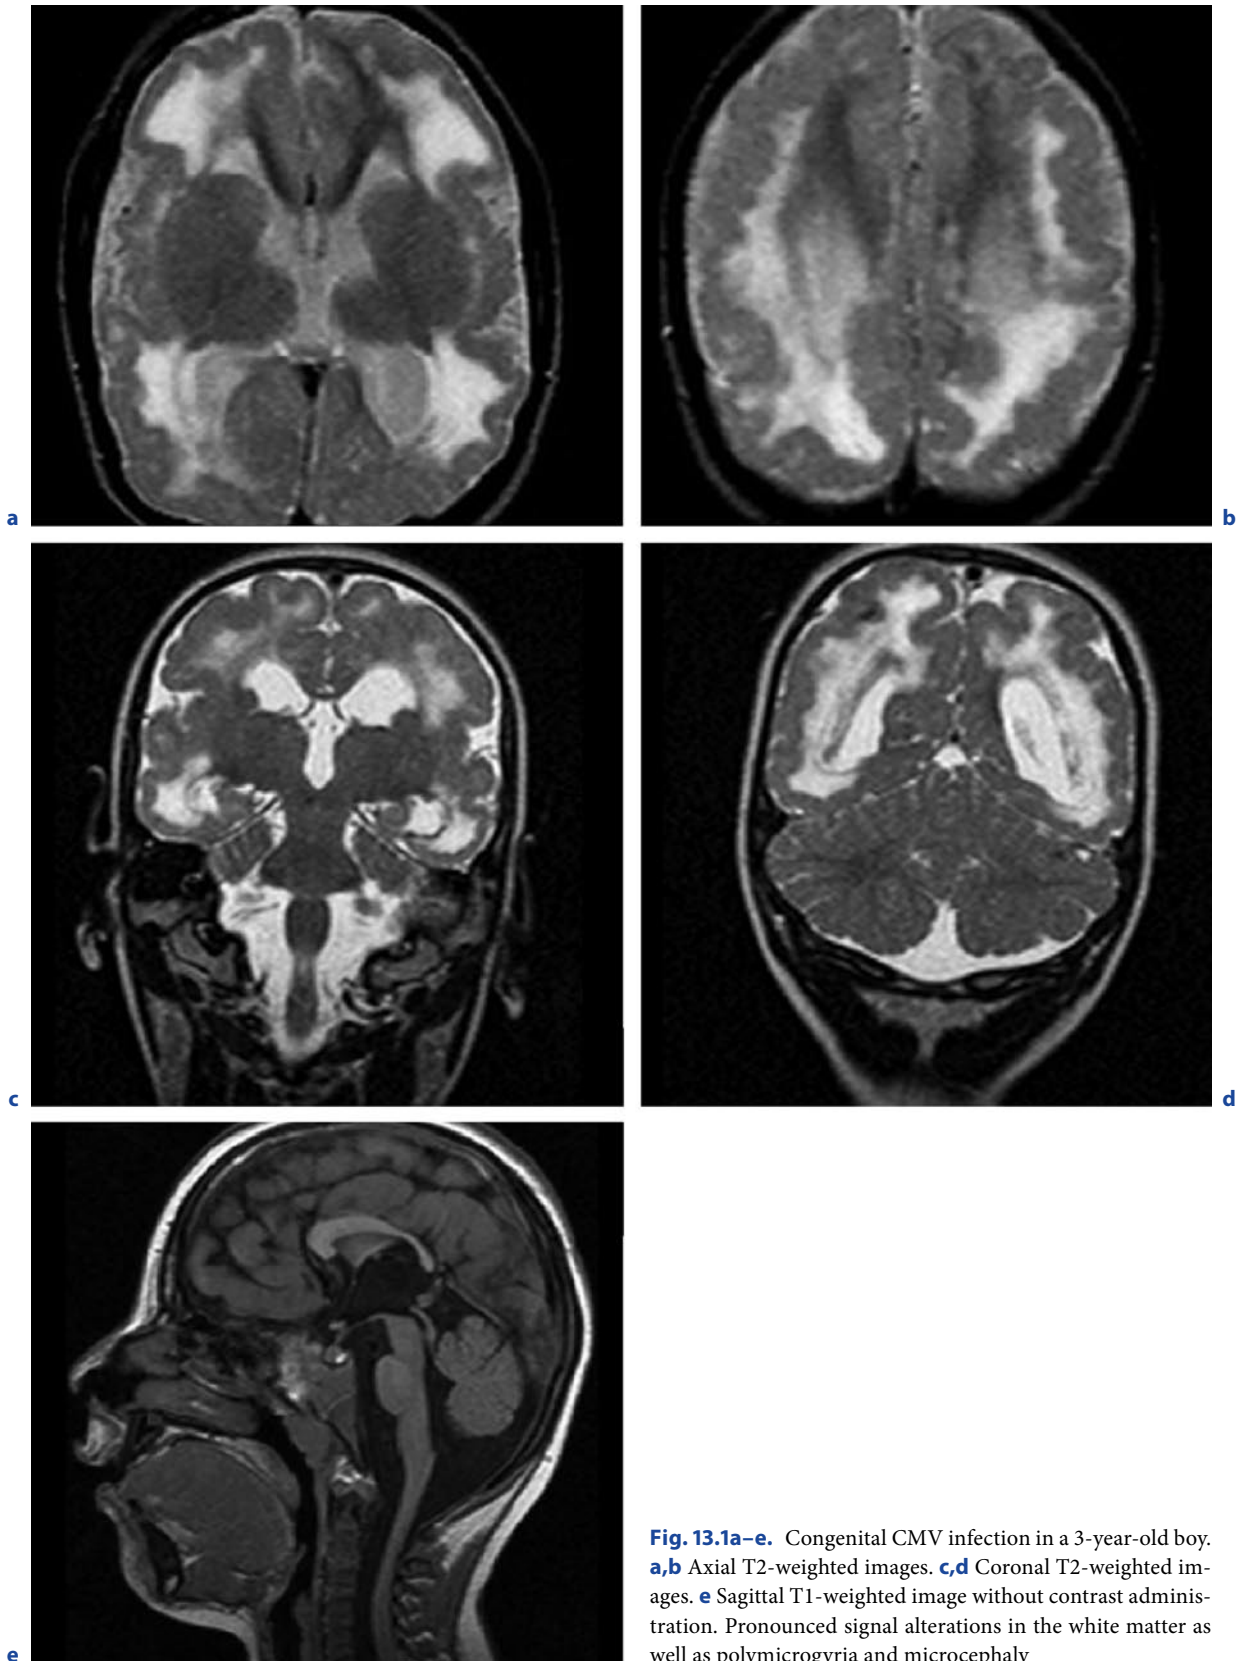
Congenital CMV infection in a 3-year-old boy. a,b Axial T2-weighted images. c,d Coronal T2-weighted images. e Sagittal T1-weighted image without contrast administration. Pronounced signal alterations in the white matter as well as polymicrogyria and microcephaly
